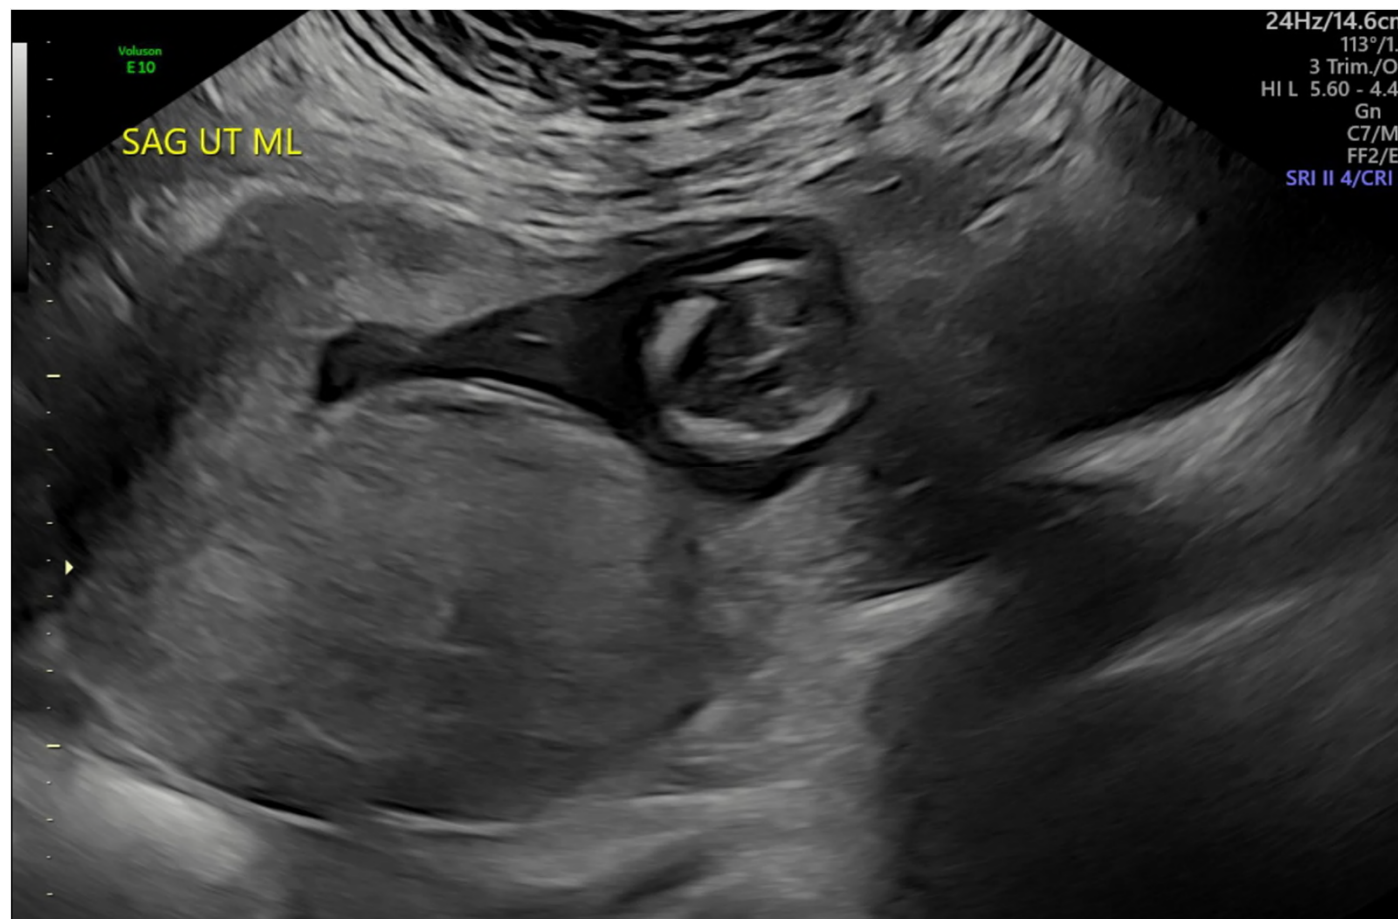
Transvaginal and transabdominal ultrasound views in control case
